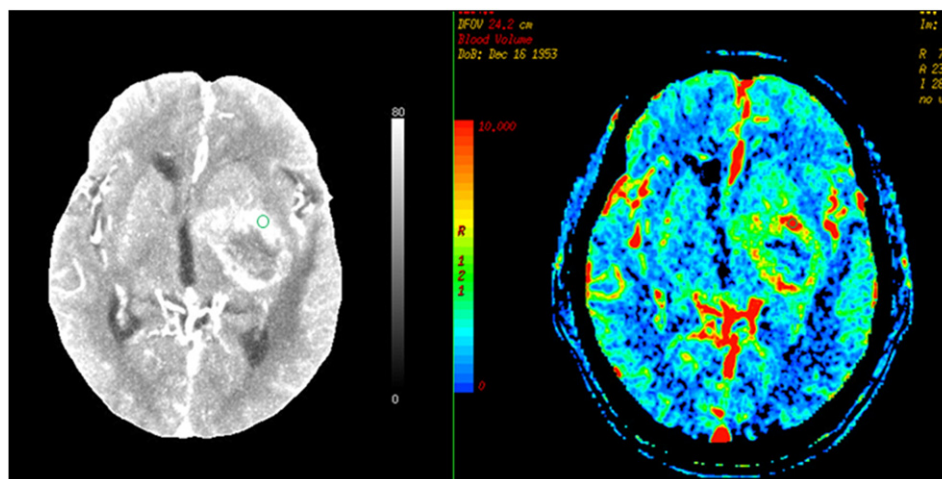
Regions of interest were manually drawn on the perfusion CT maps to include the greatest visually enhanced region or solid portion of the mass.
